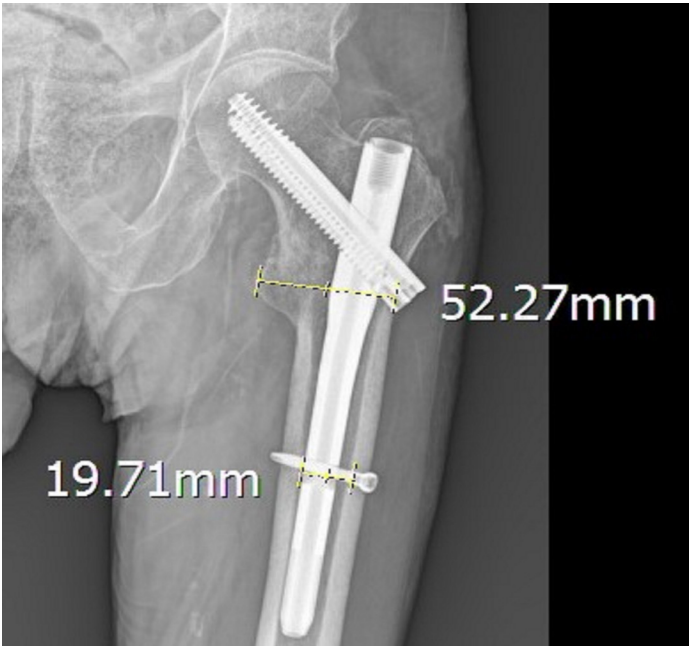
Morphological cortical index measurements on AP radiography of Hip
